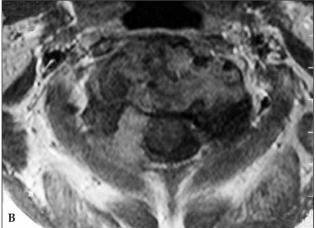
A (sagittal) T1-weighted MRI. Without contrast image revealing hypo and hyperintense lesion on the body of the axis. The protrusion into the pharynx and obliteration of the anterior subarachnoid space are also seen. B (axial) Postcontrast axial imaging showed the lesion with heterogenous intensity.
